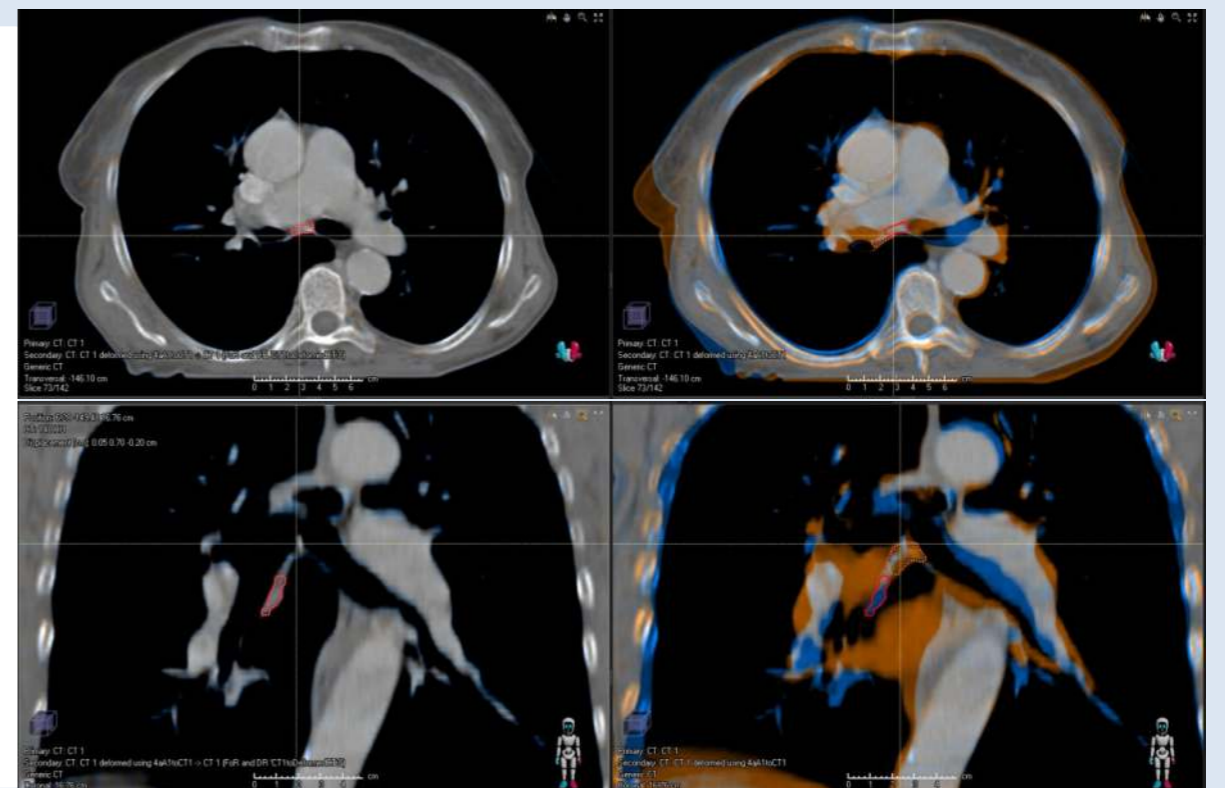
Isotropic margin expansion (IME) of 1 cm to the LN7 volume (IEM) would be needed to include the volume based on CBCT for the Pat4 and 4th Fraction CBCT.
